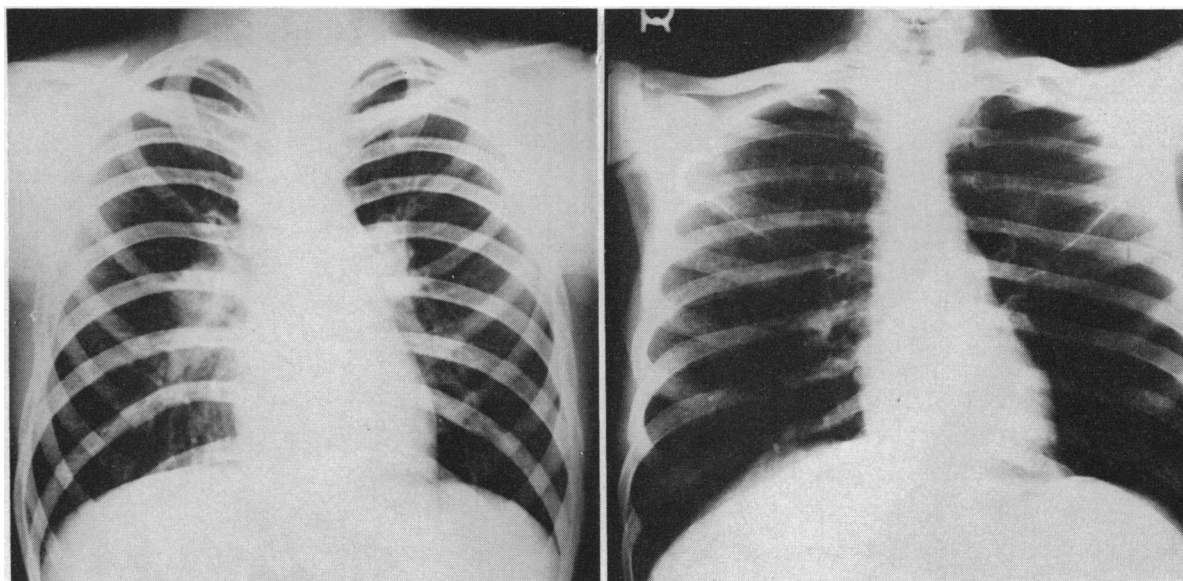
X-ray film of the chest, showing hilar adenopathy in 1947 on the left and in 1960 on the right.
